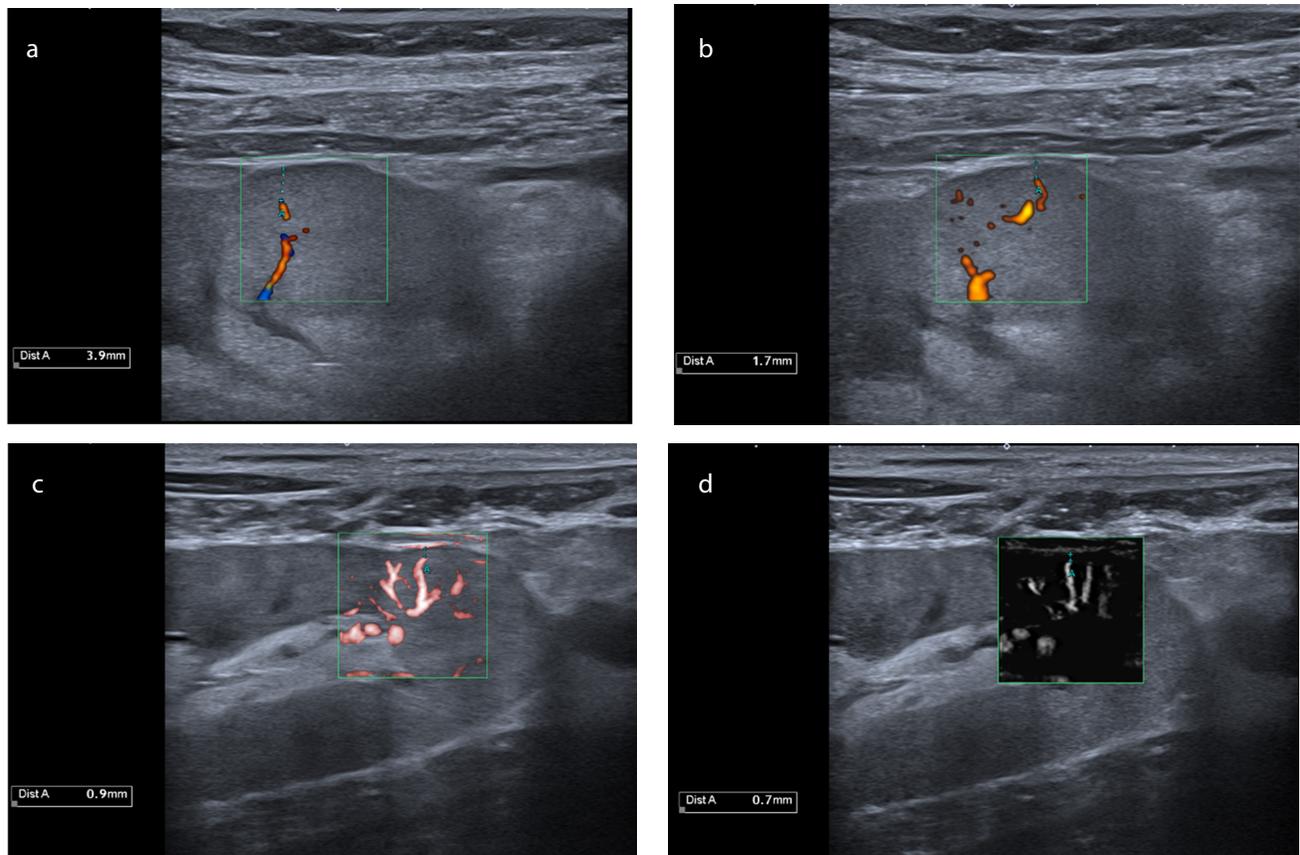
In a thirty-year-old male patient who underwent kidney transplantation five years ago, the distance between the kidney capsule and the vessel was measured as 3.9 mm on (a) color Doppler ultrasound, 1.7 mm on (b) power Doppler ultrasound, 0.9 mm on (c) color superb microvascular imaging examination, and 0.7 mm on (d) monochrome superb microvascular imaging examination. The chronic allograft damage index (CADI) score was calculated as 6. The patient was in the high CADI group. The capsule–vessel distances measured by the Doppler examinations were above the cut-off values and correlated with the pathology result. The resistive index was calculated as 0.58, and serum creatinine was 4.54 mg/dL.
